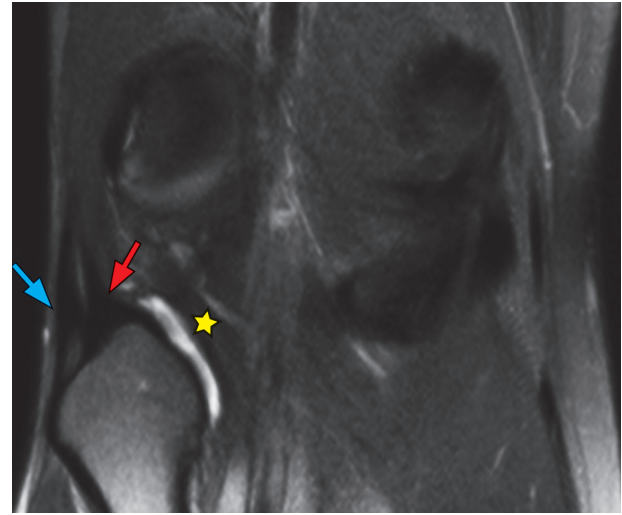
The insertion of the biceps tendon (blue arrow) and the collateral ligament (red arrow) onto the fibular head is seen on this coronal T2-weighted, fat-saturated image. Usually its attachment is not separate as in this case (see Fig. 6.2). A small quantity of fluid through the popliteus hiatus clearly highlights the popliteal tendon (asterisk).
